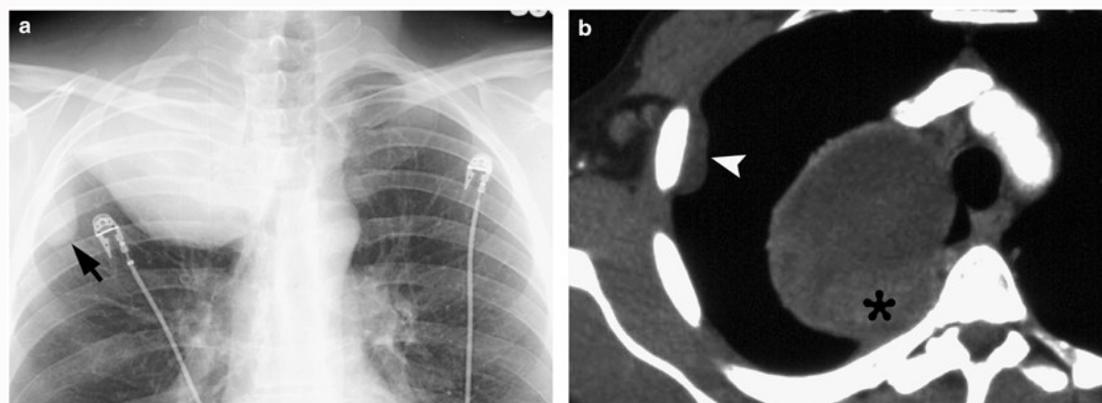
Synovial sarcoma in a young man with shortness of breath. Chest radiograph (a) demonstrates right apical mass. A pleural-based nodule (arrow) lies inferiorly. Contrast-enhanced CT scan (b) demonstrates a cystic pulmonary mass with thickened wall (asterisk) and a metastatic nodule (arrowhead) along lateral pleuron.
